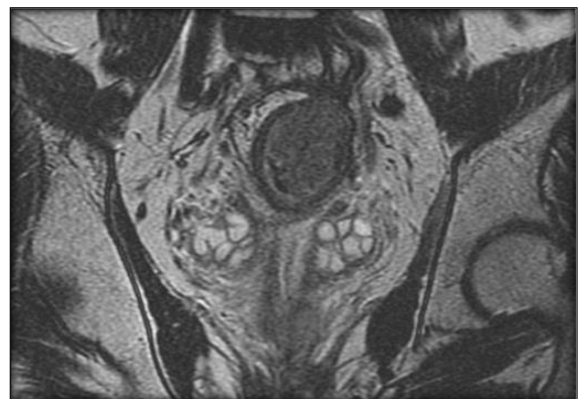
CORONAL T2W MRI shows circumferential mid-lower rectal tumor appearing intermediate to high signal intensity
